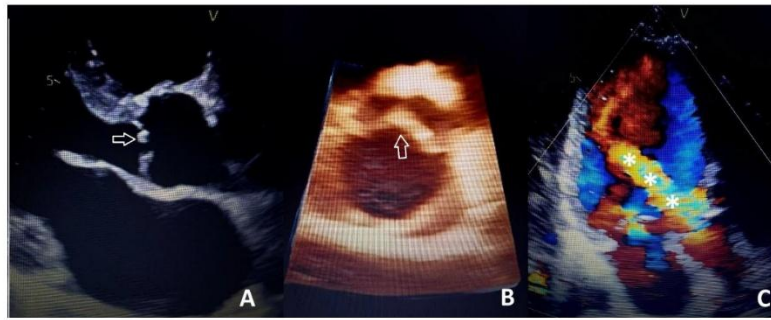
Transthoracic echocardiogram in a 38-year-old male patient. A: Parasternal long-axis view showing the aortic valve with thickening, deformity, and retraction of the right coronary cusp (arrow). B: Three-dimensional parasternal short-axis view showing the aortic valve with thickening, deformity, and retraction of the right coronary cusp (arrow). C: Apical three-chamber view with severe aortic regurgitation on color Doppler (asterisks).
